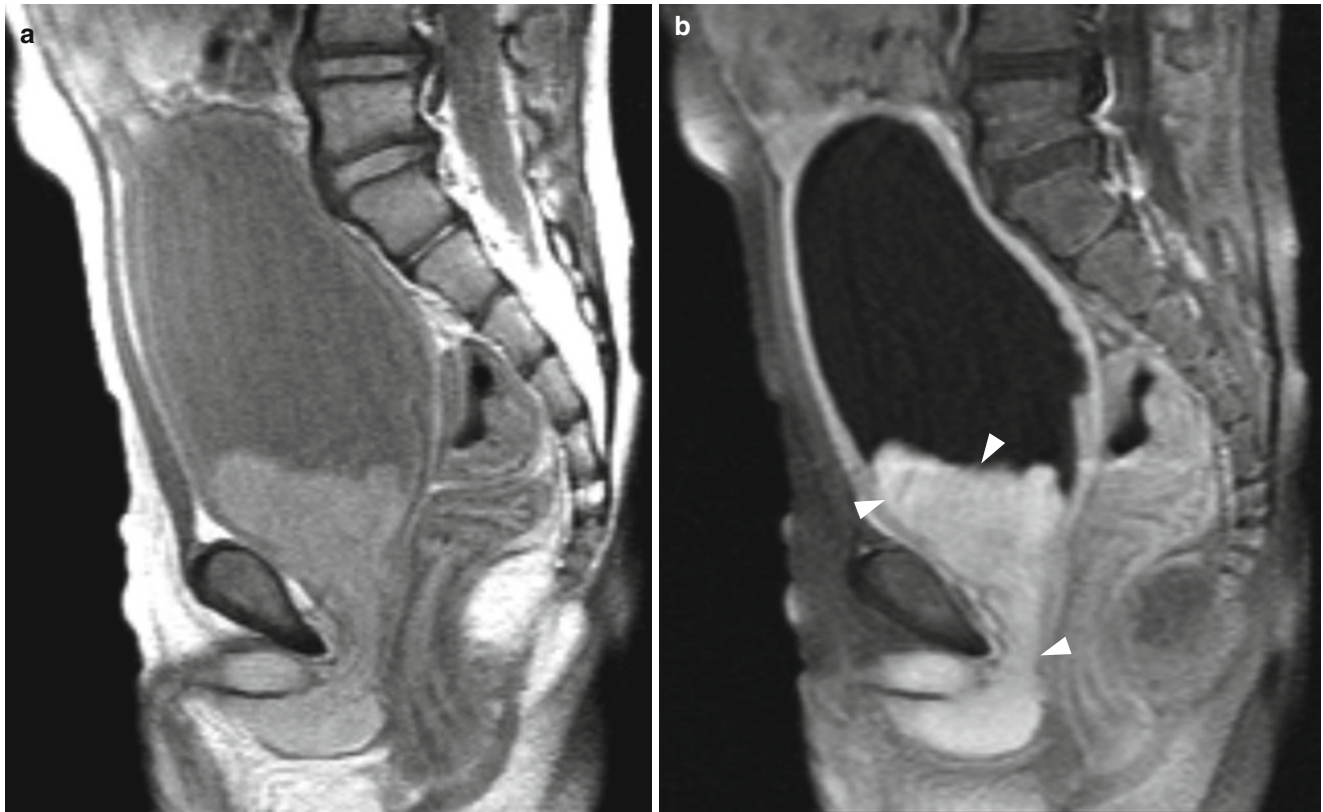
Embryonal rhabdomyosarcoma in a 3-year-old male. (a, b) Sagittal T2-weighted (a) and contrast-enhanced T1-weighted (b) MR images show a lobulated mass (*arrowheads*) extending from the bladder base to the prostatic urethra
